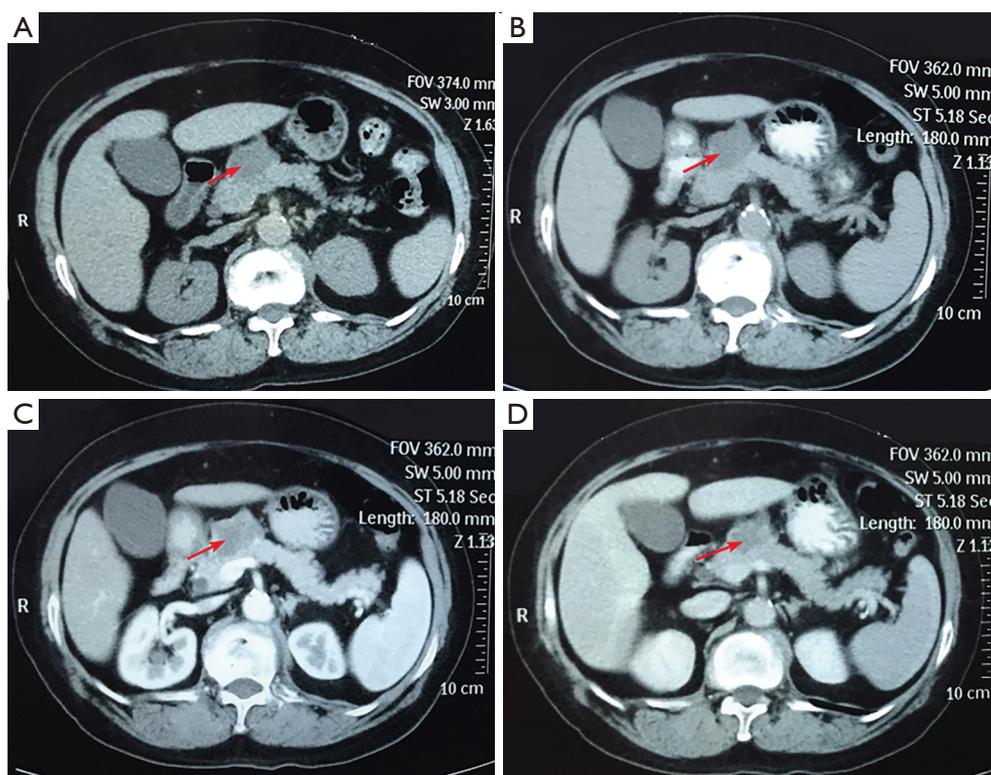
Computed tomography showing a pancreatic mass (red arrows).
